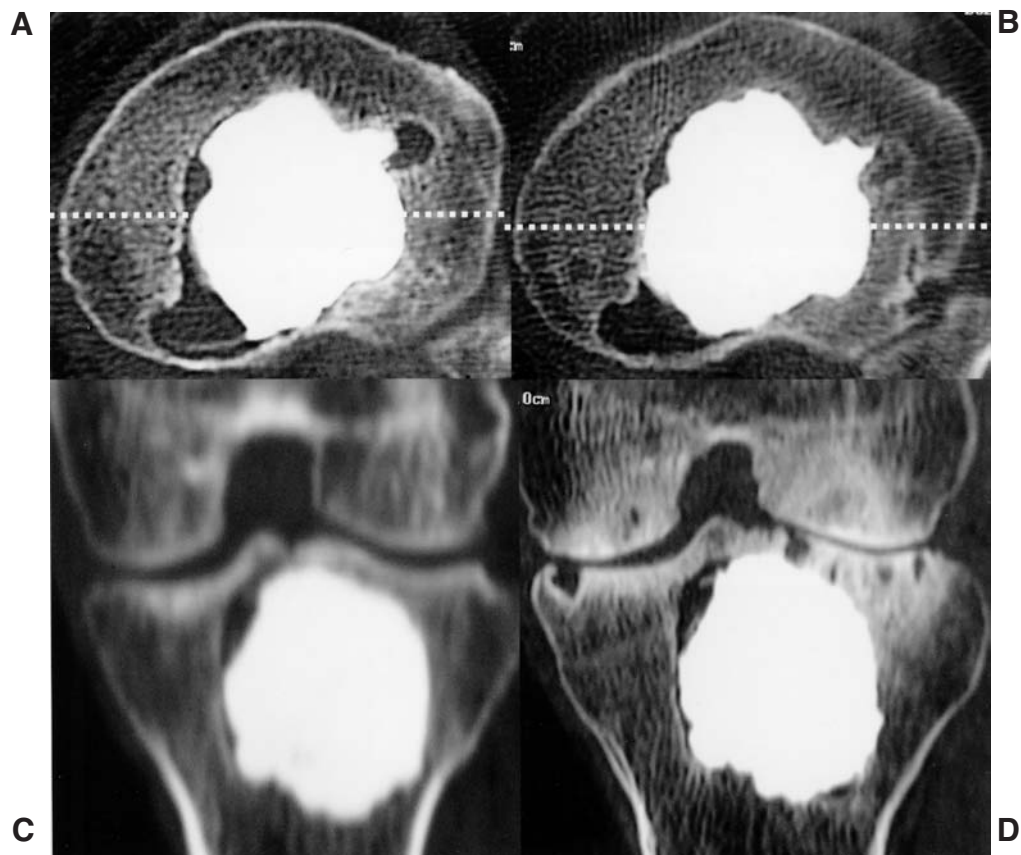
A and C. Axial and coronal views of single-helical CT scan one month after surgery. B and D. Axial and coronal views of 16 multidetector CT 4.5 years after surgery.
